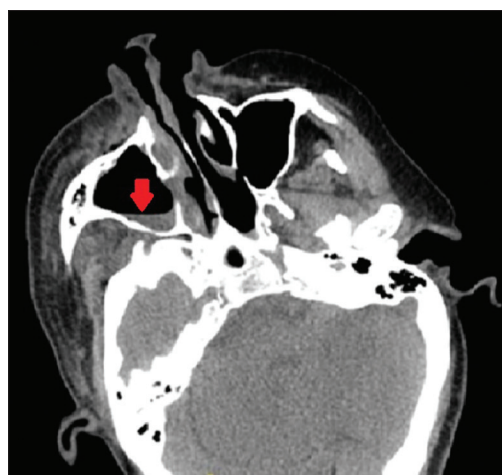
Axial section of CT PNS: Right-sided maxillary sinusitis with rarefaction and thinning of the bony walls (arrow)
